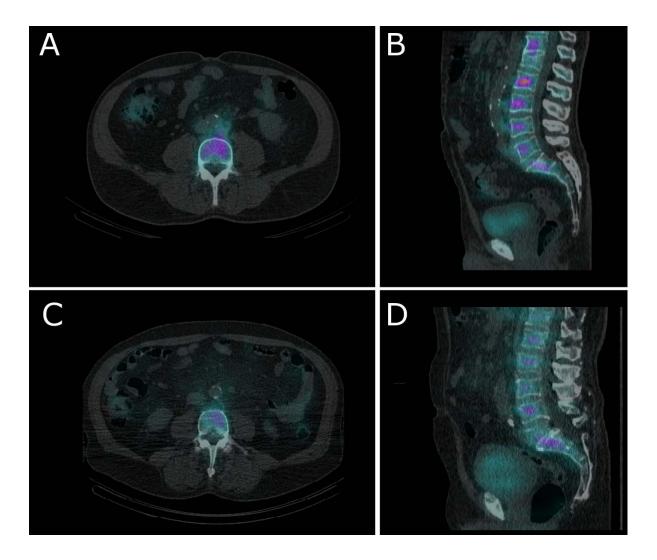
(A and B) Axial and sagittal fused SPECT/CT-images of patient 13 at 96 hours after ¹⁷⁷Lu-lilotomab satetraxetan injection. This patient did not receive pre-dosing with lilotomab. The L4 lumbar vertebra can be seen in the axial slice. Uptake of activity is observed in the vertebrae and the sacrum; the uptake in L2-L4 was quantified and used for RM dosimetry. (C and D) SPECT/CT images of patient 9. This patient received pre-dosing with lilotomab.
